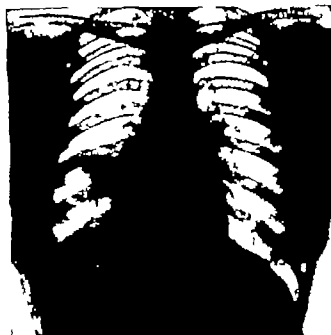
The patient, aged twenty-nine had had pleurisy two years previously with a history of having been needled and a (?) phrensectomy. Two weeks prior to the X-ray examination there was a recurrence of pain on the right side of the chest, with a cough and sputum. There was no hemoptysis. He had gained 5 lb. during the year. The teleradiogram shows an opacity in the region of the right middle lobe.
